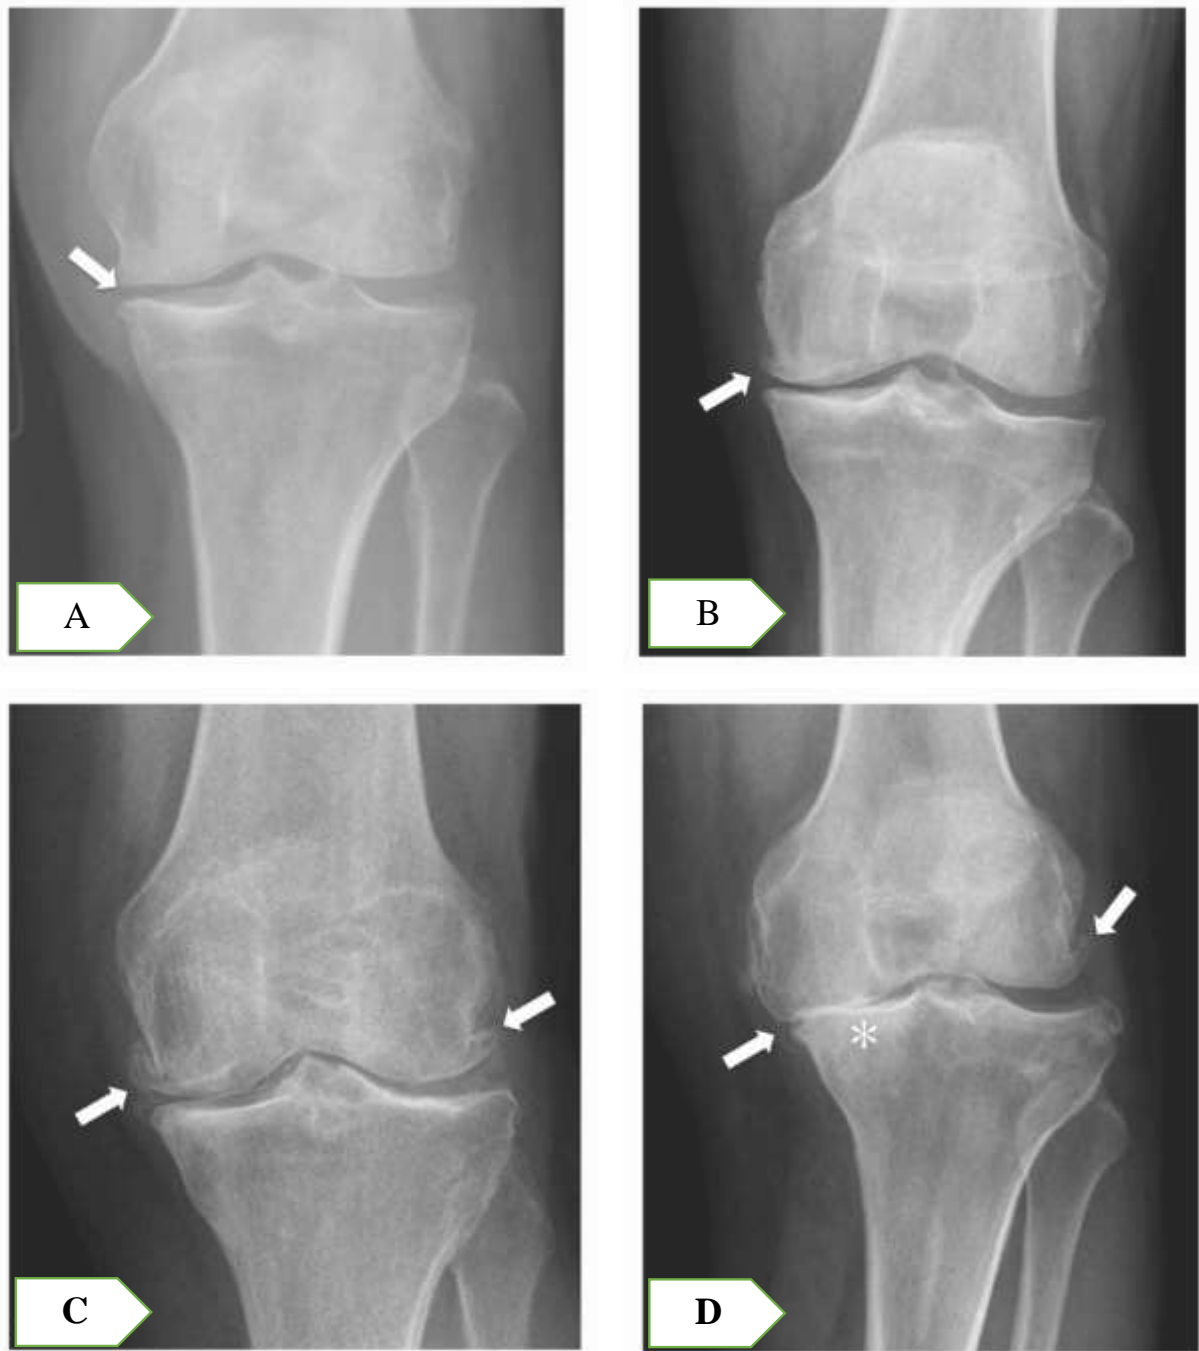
Radiograph for Knee OA Diagnosis
